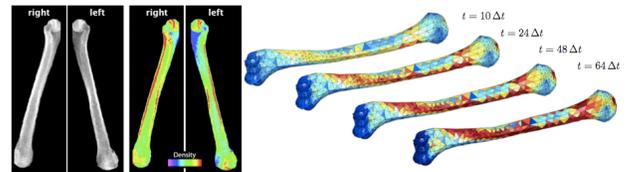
X-rays of left and right arms of a competitive tennis player (A and B) showing a 24% higher bone mass density in the right humerus. Longitudinal growth: Time sequence of density adaptation in maximum shoulder rotation loads agrees with observed density changes (C).
